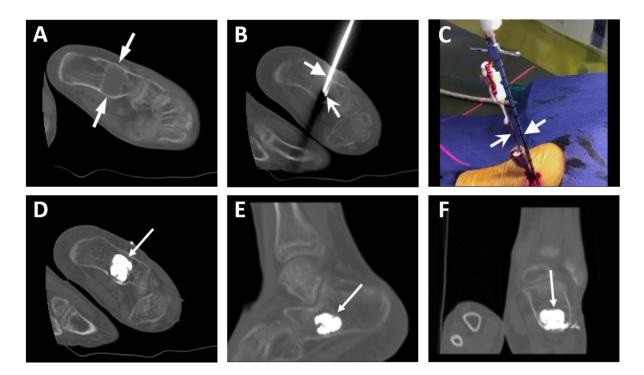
(A) – Axial noncontrast CT image of the right hind foot shows the intraosseous sharply marginated calcaneal lesion (arrow). (B, C) Under CT fluoroscopy guidance, a VerteStable cannula (thick arrow) and an Ostycut needle (wide arrow) were inserted percutaneously into the cyst for the injection of a radiopaque bone cement mixture. The radiopaque bone cement mixture was injected through the VerteStable cannula until there was no more serosanguineous fluid efflux from the Ostycut needle, and only cement mixture efflux was observed. (D–F) The actual noncontrast CT image and reconstructed sagittal and coronal images show a complete replacement of cyst content with radiopaque cement material (thin arrow).
